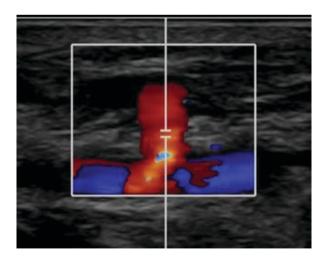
Duplex ultrasound demonstrating a radial pseudoaneurysm after transradial catheterization in the longitudinal view
